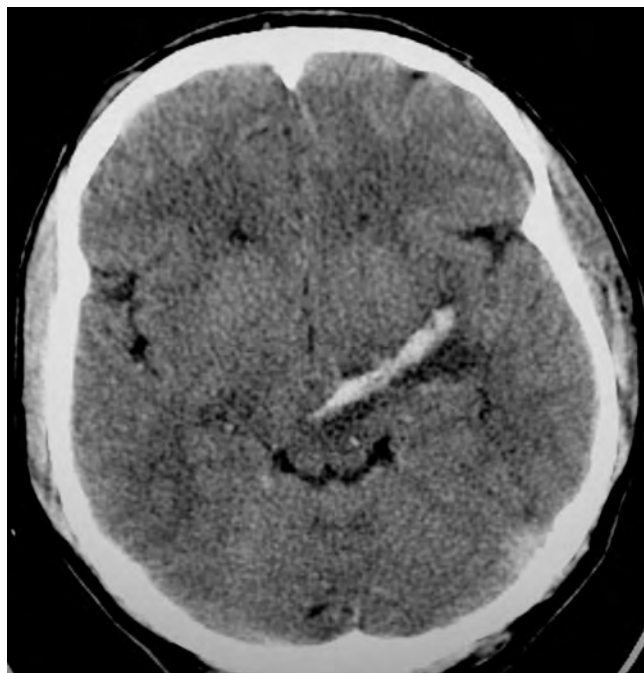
Non-contrasted cranial CT scan showing hyperdense trajectory of penetrating weapon through temporal parenchyma to midbrain affecting left cerebral peduncle.
